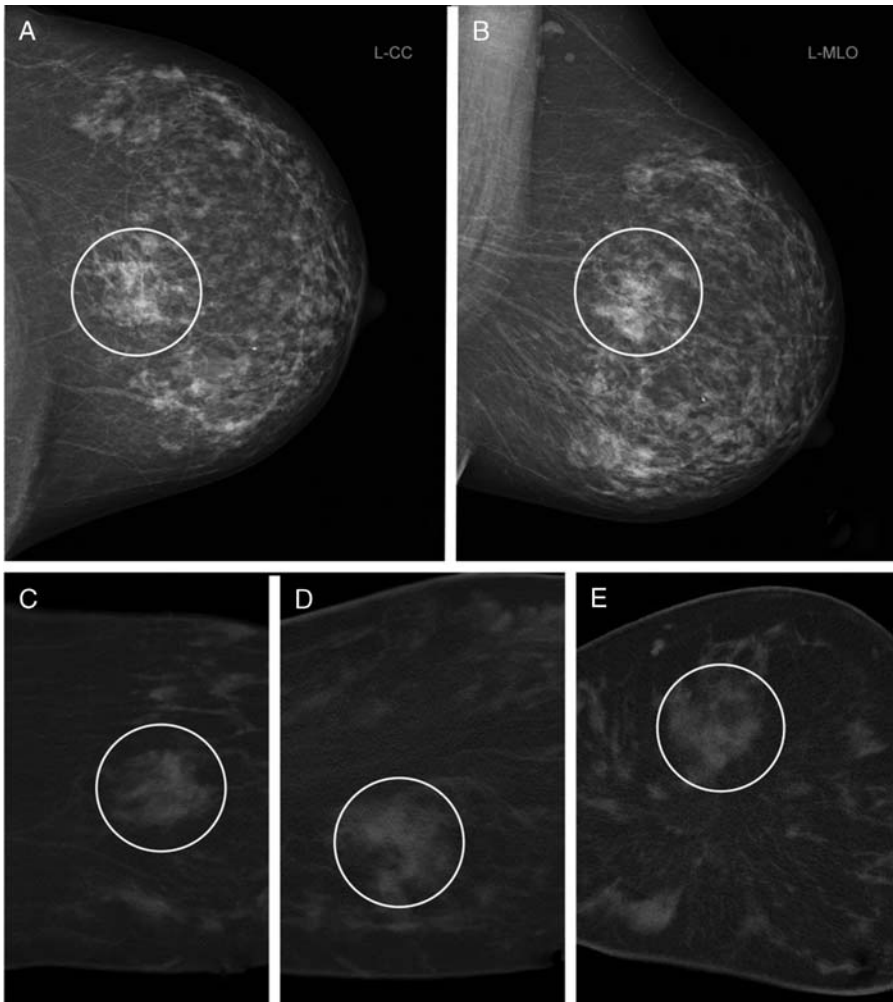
A 67-year-old patient with focal prepectoral density in mammography (A and B) with no correlation in ultrasound. In B-CT (C-E), the density presented as normal breast tissue. Nevertheless, an additional MRI was performed, which was normal. C, Axial reconstruction. D, Sagittal reconstruction. E, coronar reconstruction, all in avgIP (10 mm).
